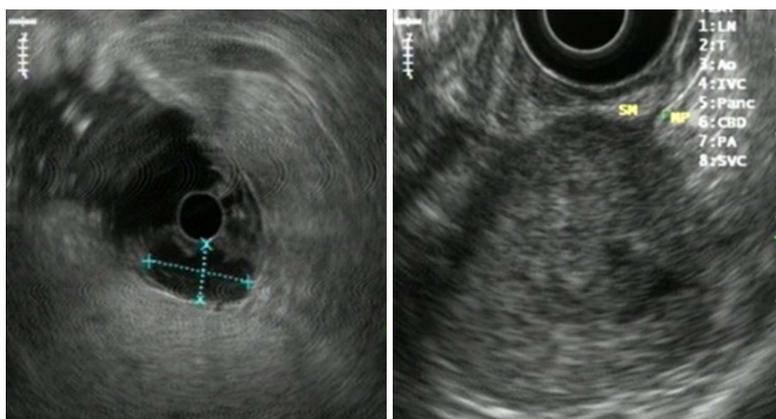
Endoscopic ultrasonography images of gastrointestinal stromal tumors.
